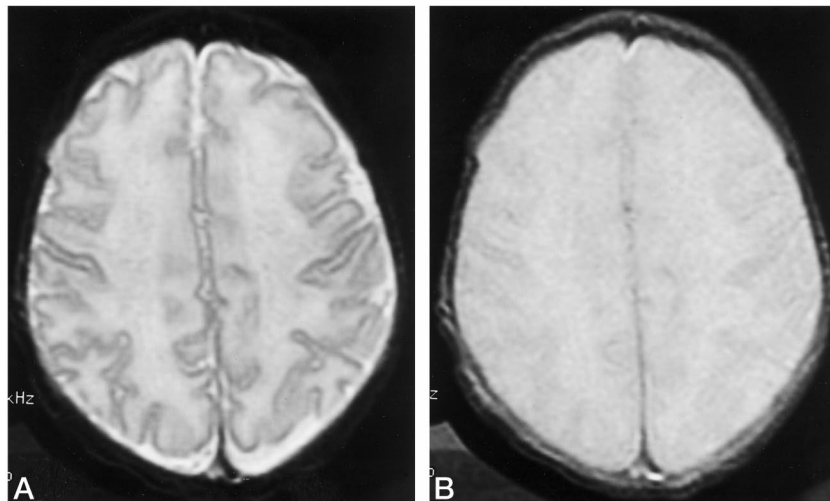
MR imaging at age 2 days shows value of first echo in an asphyxiated neonate, who was found to have both motor and cognitive deficits at age 12 months.
